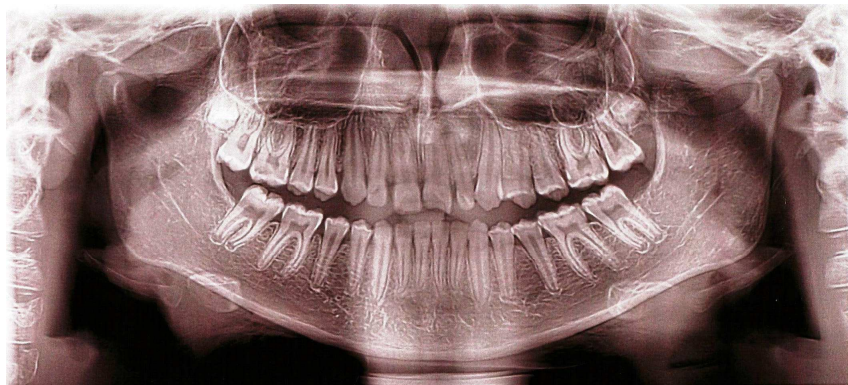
Permanent dental occlusion in a patient aged 24 years with developmental disorders 18, 28, 38, 48. On the upper jaw there are wisdom teeth, which are in a retained state, on the lower – the absence of their formation (orthopantomogram).
